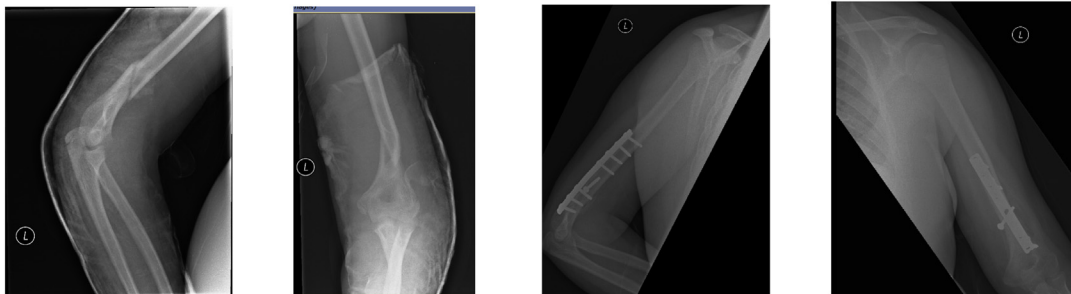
Radiographs: Humeral shaft fracture, pre and post open reduction and internal fixation.
